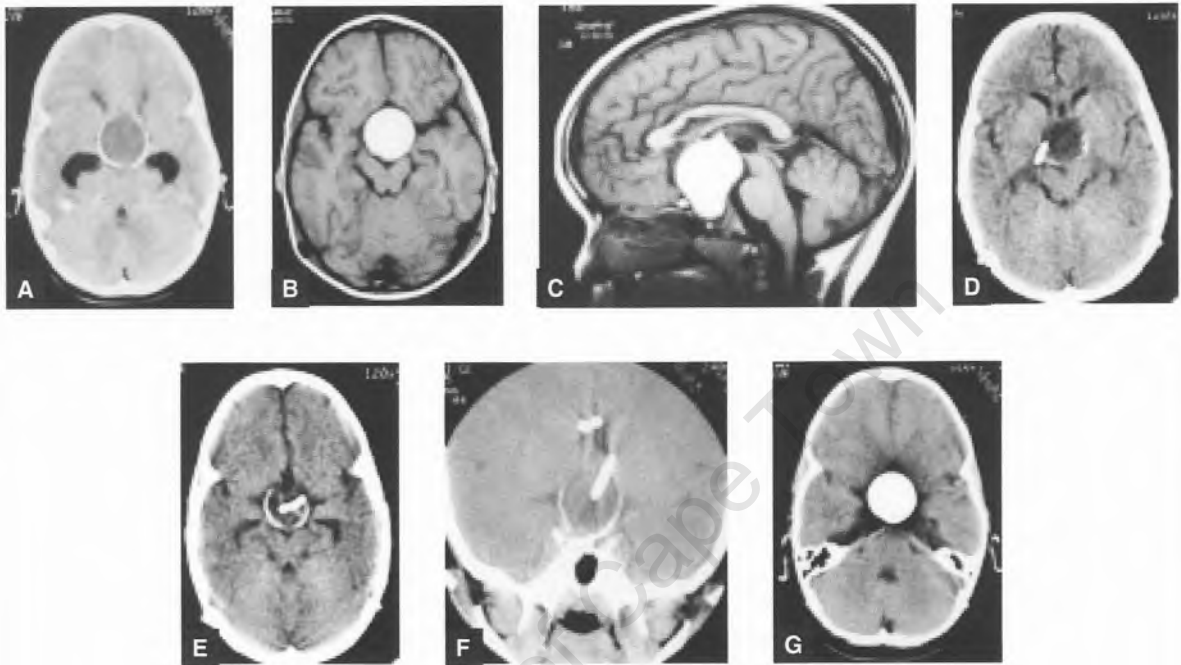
Initial CT scan showing a suprasellar cystic tumour with a densely calcified wall and accompanying hydrocephalus (a). Axial (b) and sagittal (c) T1 weighted MRI scans confirming extension from the sella into the third ventricle. CT scans after each of the two stereotactic operations showing the catheter alongside the cyst after the 1<sup>st</sup> operation (d) and within the cyst after the 2<sup>nd</sup> (e), confirmed on a coronal reconstruction (f) and contrast cystogram (g).
